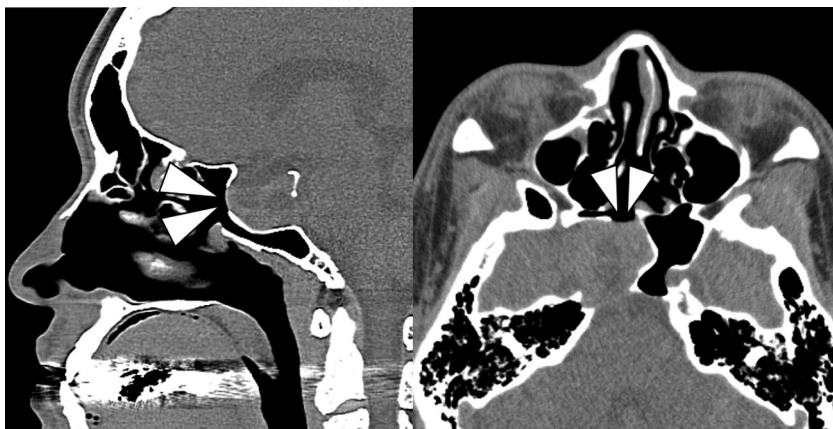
Radiographic examination of the skull base was performed before orthognathic surgery. Right panel: sagittal CT scan demonstrating the bone defect in the sella turcica (arrowhead). Left panel: axial CT scan demonstrating the same bone defect (arrowhead).
